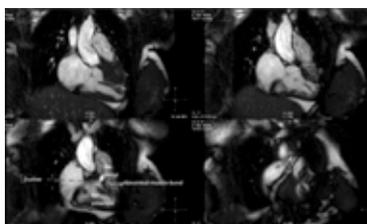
The appearance of DCRV with cardiac magnetic resonance imaging.
